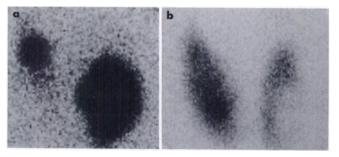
Stage II thyroid scintigram (A) before and (B) after treatment of a hot nodule with Plummer's disease.
